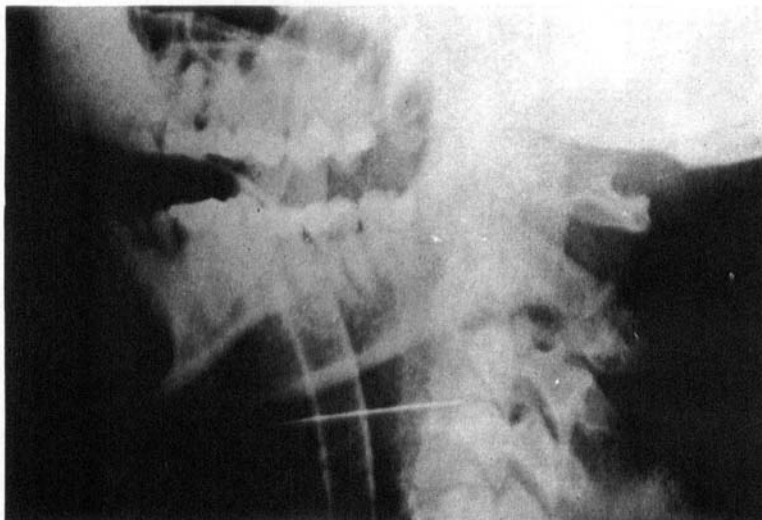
Initial lateral X-ray of the fracture dislocation of C-2 on C-3.*
